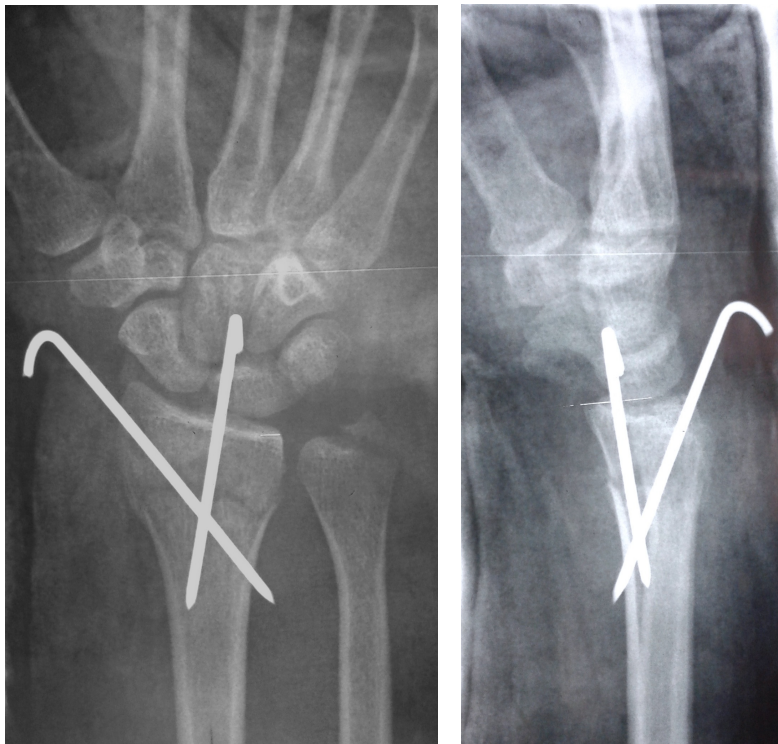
X-ray demonstrating reduction of the fracture maintained with two percutaneous pins (Courtesy of CMJAH, Gauteng Health Department)
